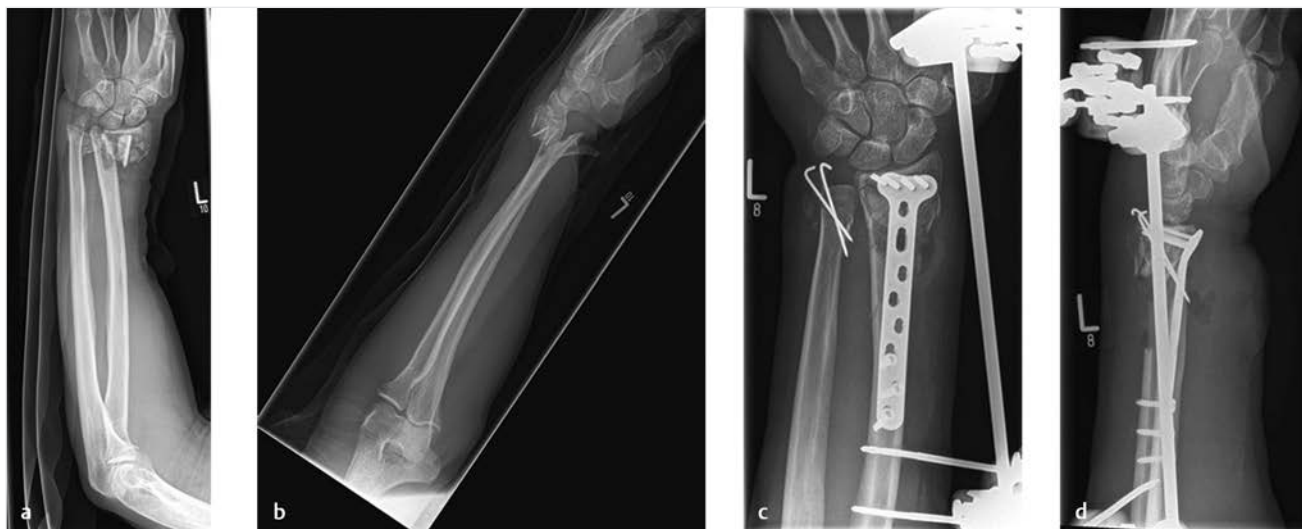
(a–d) X-ray images of the initial (open) fracture with related initial operative treatment.
